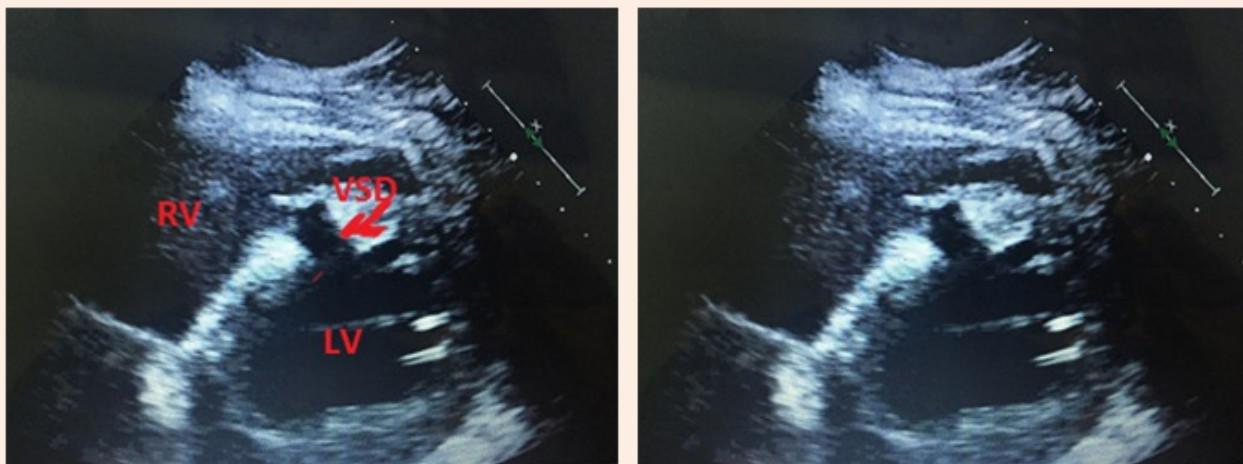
Post MI VSD by echocardiography.
